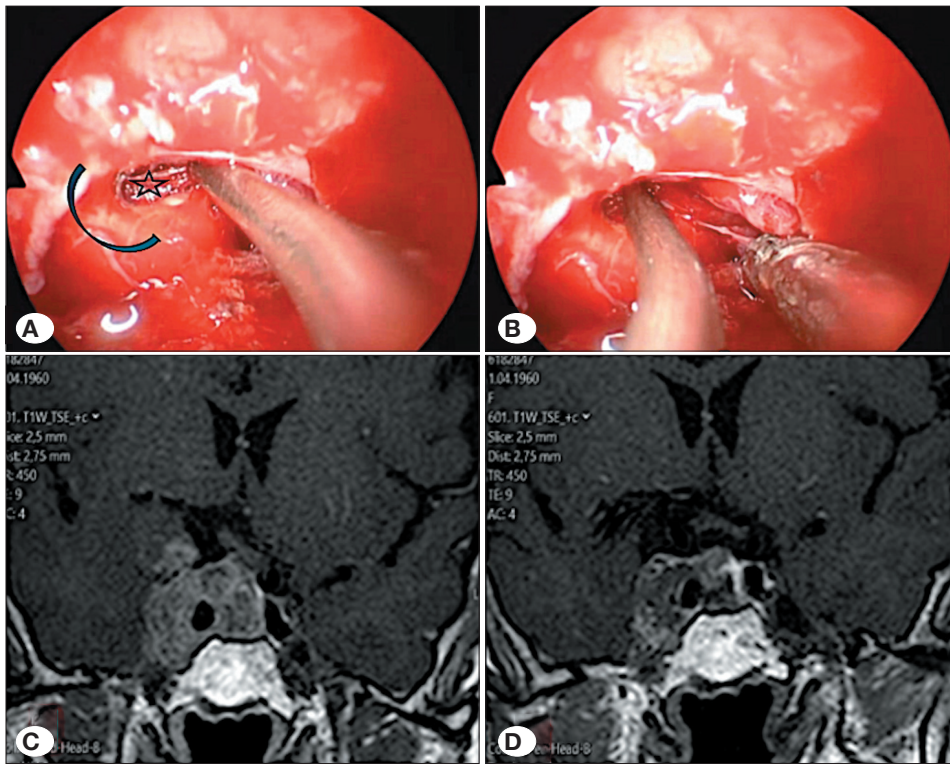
A) This case presents a variation in the anatomy of the internal carotid artery. The tumor is excised by directly accessing the superior and lateral compartments through the medial corridor (MC). Atherosclerotic changes within the horizontal segment extending toward the midline are clearly observed. The medial corridor is delineated by dense fibrotic bands, marked with a star. B) The tumor tissue is accessed via the MC using an aspirator, and surgical excision is performed. C,D) Pre- and postoperative magnetic resonance imaging demonstrating the tumor status before and after resection.
